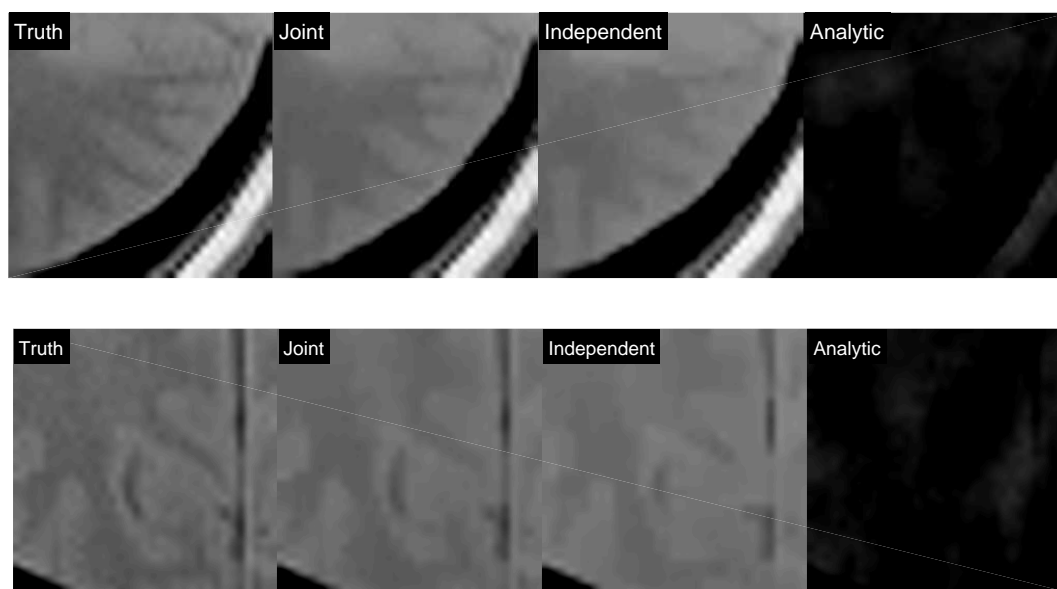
ROI comparison for MRI images with all three ROIs being defined in Fig. 5.16 in red; All ROIs are zoomed in with zoom factor of $8\times$. Display window is $[0 \ 1]$.
